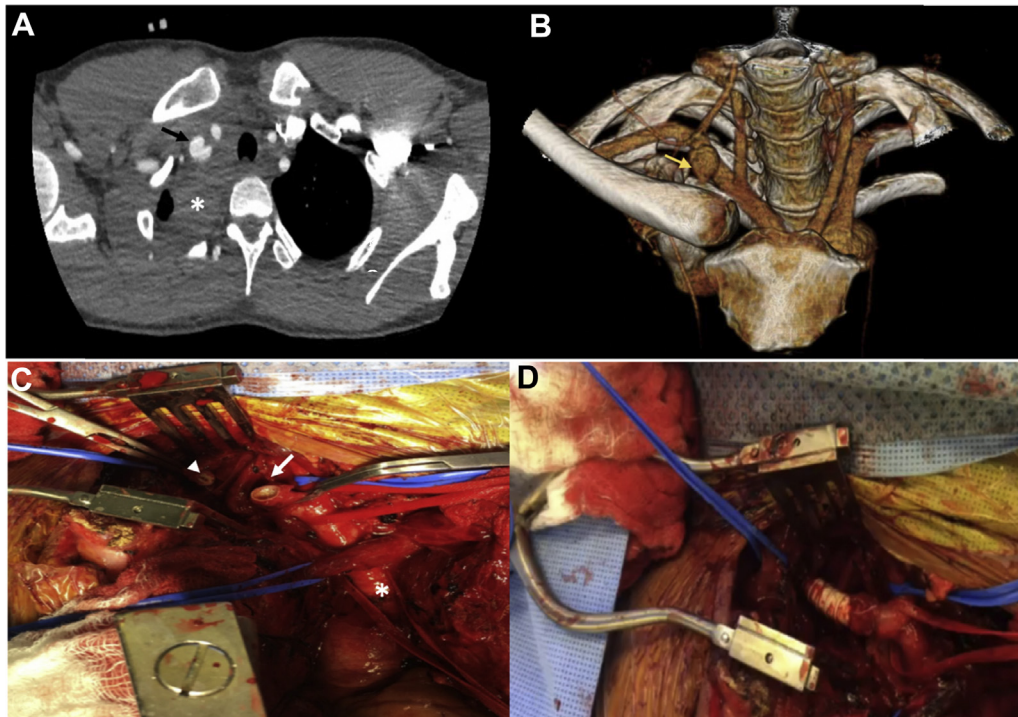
A, Computed tomography angiography (axial image) demonstrating the right subclavian artery pseudoaneurysm (arrow) with surrounding mediastinal hematoma (asterisk). B, Three-dimensional reconstruction of computed tomography angiography image demonstrating the right subclavian pseudoaneurysm (arrow). C, Ruptured right subclavian artery, proximal edge (arrow), distal edge (arrowhead), and innominate artery (asterisk). D, Right subclavian artery repair with interposition ringed polytetrafluoroethylene graft.
